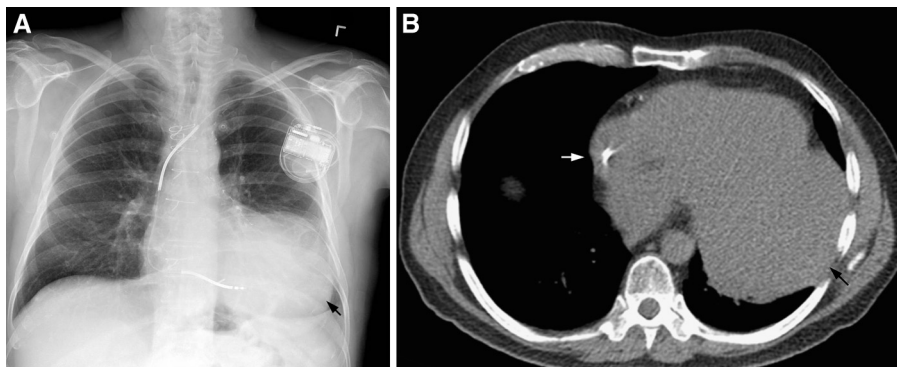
Large left ventricular aneurysm (black arrows) in a patient with previous lateral wall myocardial infarction. The aneurysm can be seen on the posteroanterior chest radiograph (A), and its dimensions are better appreciated on the axial noncontrast computed tomography image (B). A single-lead implantable cardiac defibrillator is also seen (white arrow), which is identifiable as a defibrillator device because the generator box is larger than a typical pacing device and a single lead with the location (right ventricular) and configuration as shown is the typical appearance of defibrillating leads.
